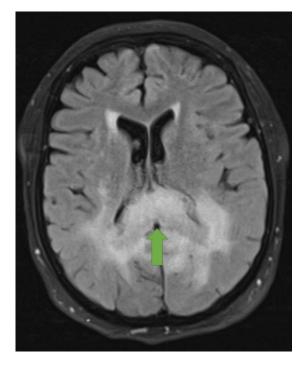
Axial projection of a T2 FLAIR weighted MRI Brain showing high signal within the corpus callosum.
